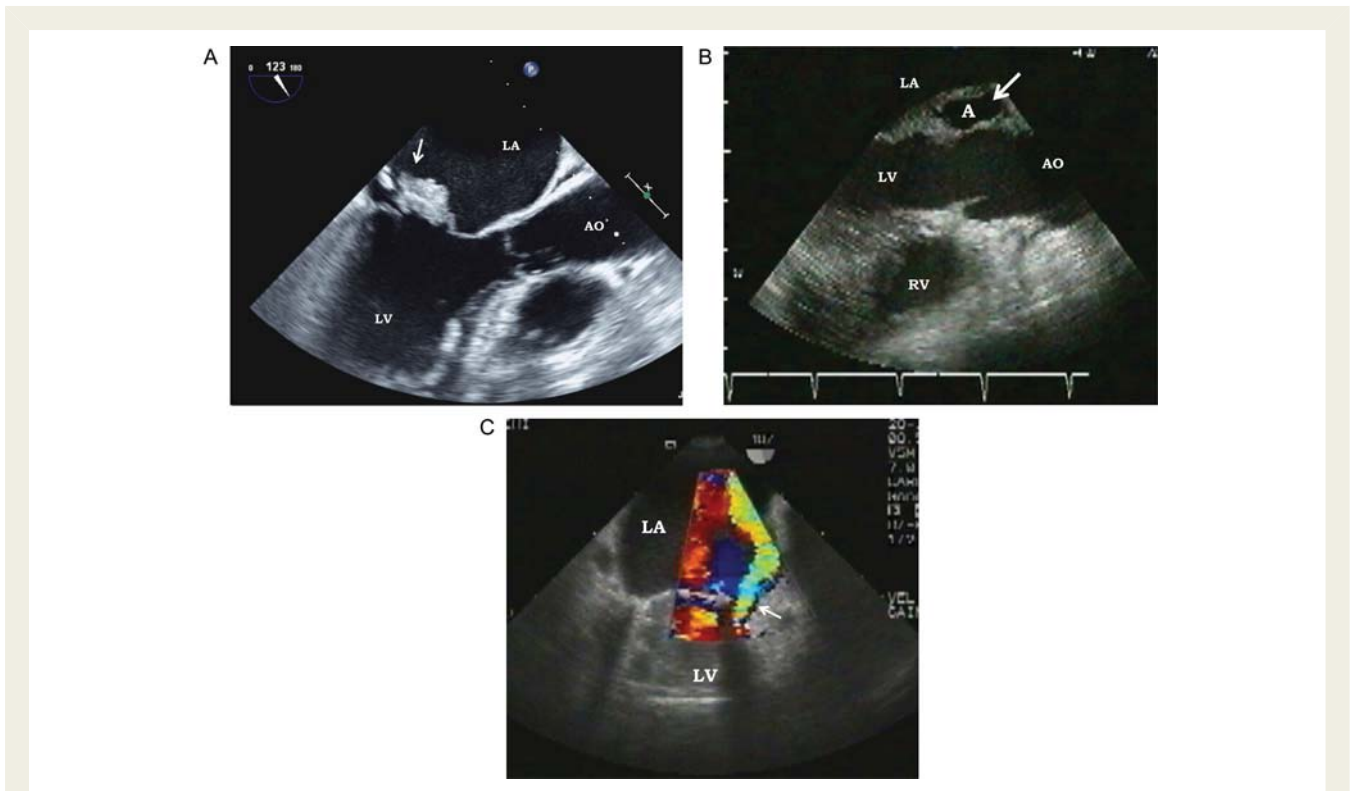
The three main echocardiographic criteria for endocarditis (TEE). (A) Large vegetation on the anterior mitral leaflet with chordae rupture (arrow). (B) Abscess: zone of reduced density (arrow) on the posterior part of the aortic root. (C) New prosthetic regurgitation (arrow) affecting a mechanical mitral prosthetic valve. LA, left atrium; LV, left ventricle; RV, right ventricle; Ao, aorta; A, abscess.
